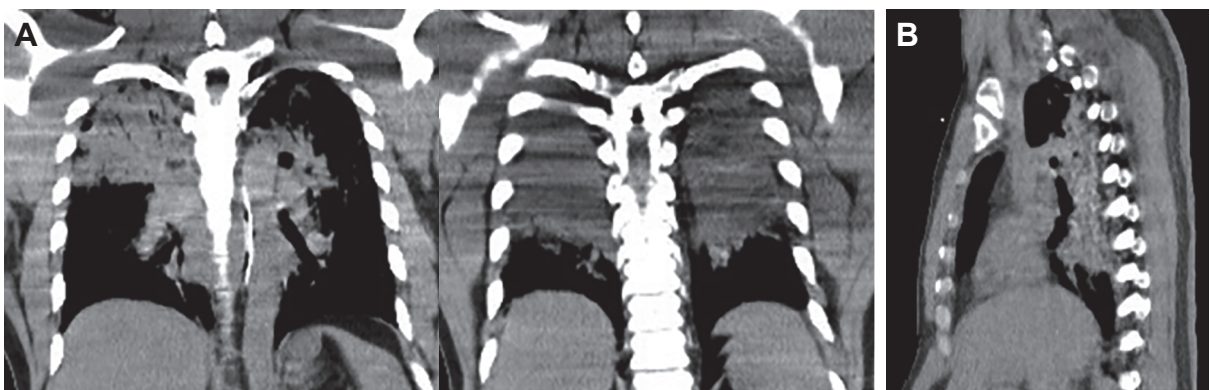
(A) The coronal view of chest CT at ER through the costovertebral junction of upper thoracic spine revealed diffuse symmetric consolidation of both lungs but spared area in the basal portions of both lungs. (B) The sagittal view of chest CT at ER through right paraspinal area demonstrated skin thickening and increased subcutaneous infiltration of the back corresponding to the lung consolidation.
